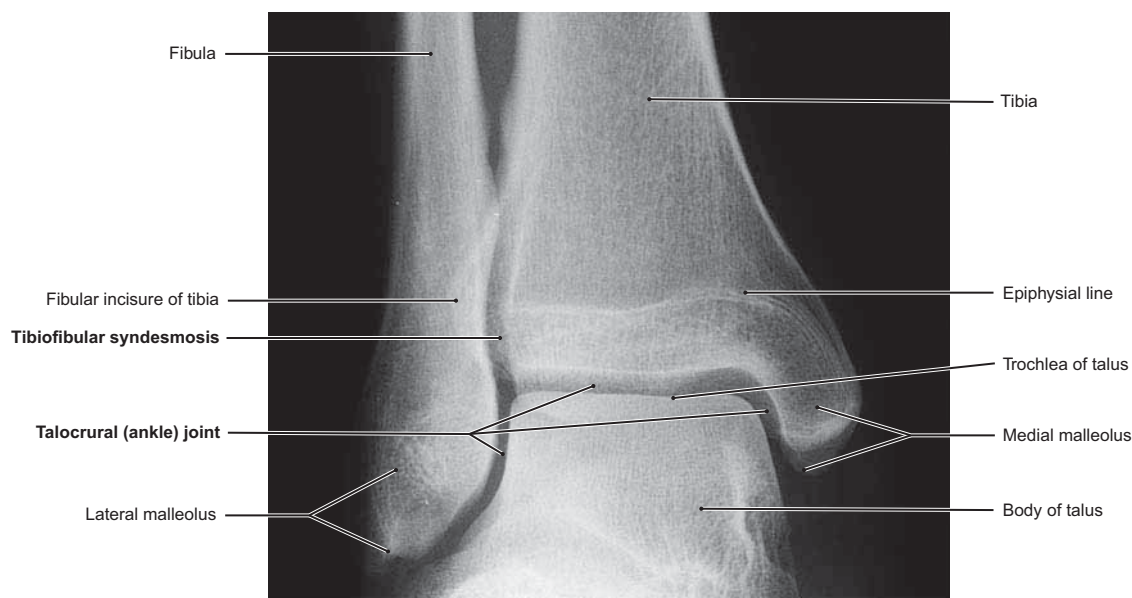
X-Ray of the Talocrural (Ankle) Joint and the Inferior Tibiofibular Syndesmosis
